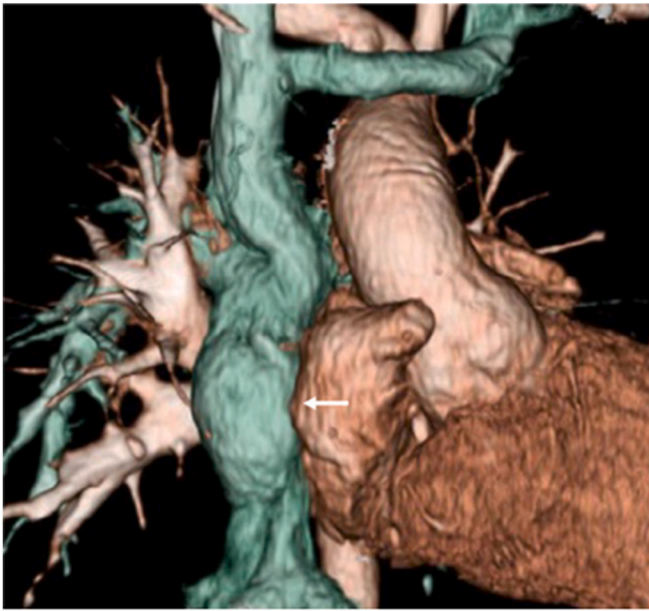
Tissue Engineered Vascular Graft. Three-dimensional computed tomography of the tissue engineered vascular graft (arrow) used as a Fontan conduit in a clinical patient. Reproduced from Ref. [100].
